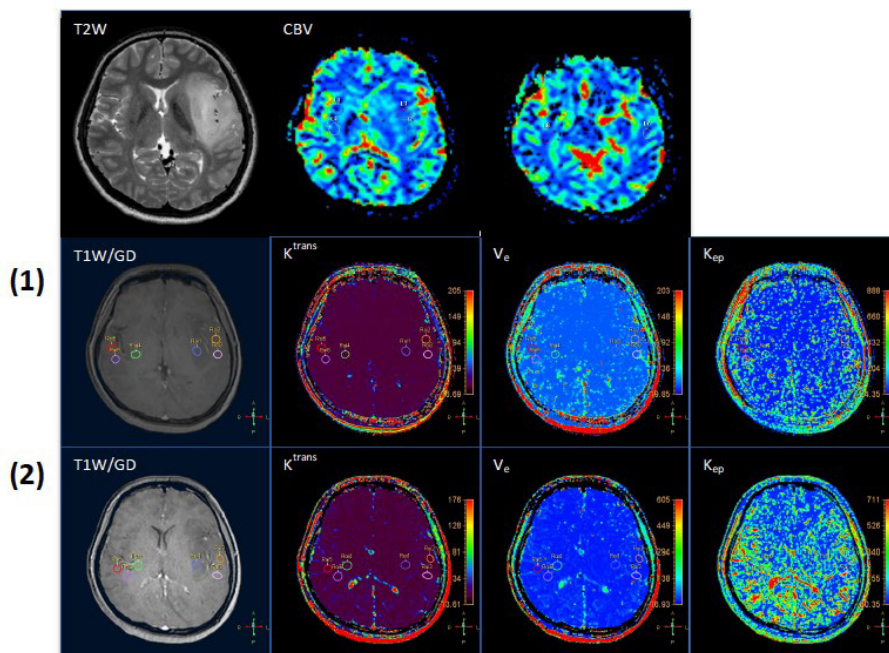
A 19-year-old female with diagnosed diffuse astrocytoma, WHO 2007 grade II. Images demonstrate ROIs in non-enhancing tumor and contralateral NAWM. T2-weighted image or FLAIR were used as a guide for tumor. CBV map from DSC-MRI and parameter maps from DCE-MRI with (1) 30 and (2) 70 dynamic acquisitions
